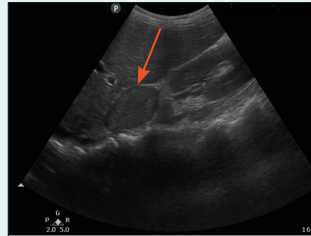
Ultrasound of the right loin.
